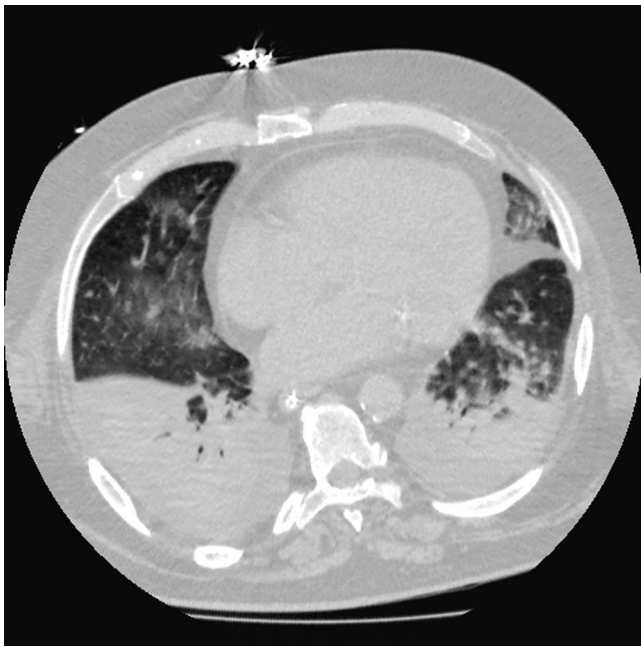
Lung computed tomography scan.
